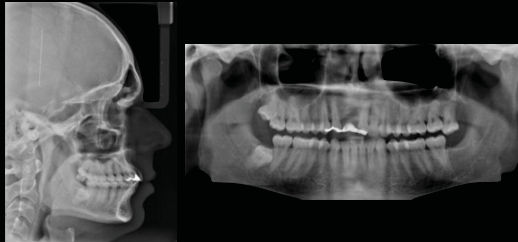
Initial profile tele-radiography and orthopantomography
